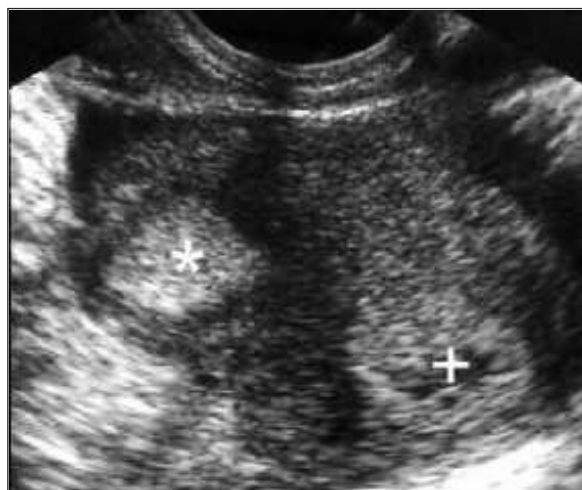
Preoperative axial sonographic scan of the uterine corpus showing two distinct endometrial linings of endometrial cancer (cross) and hyperplasia (asterisk).
